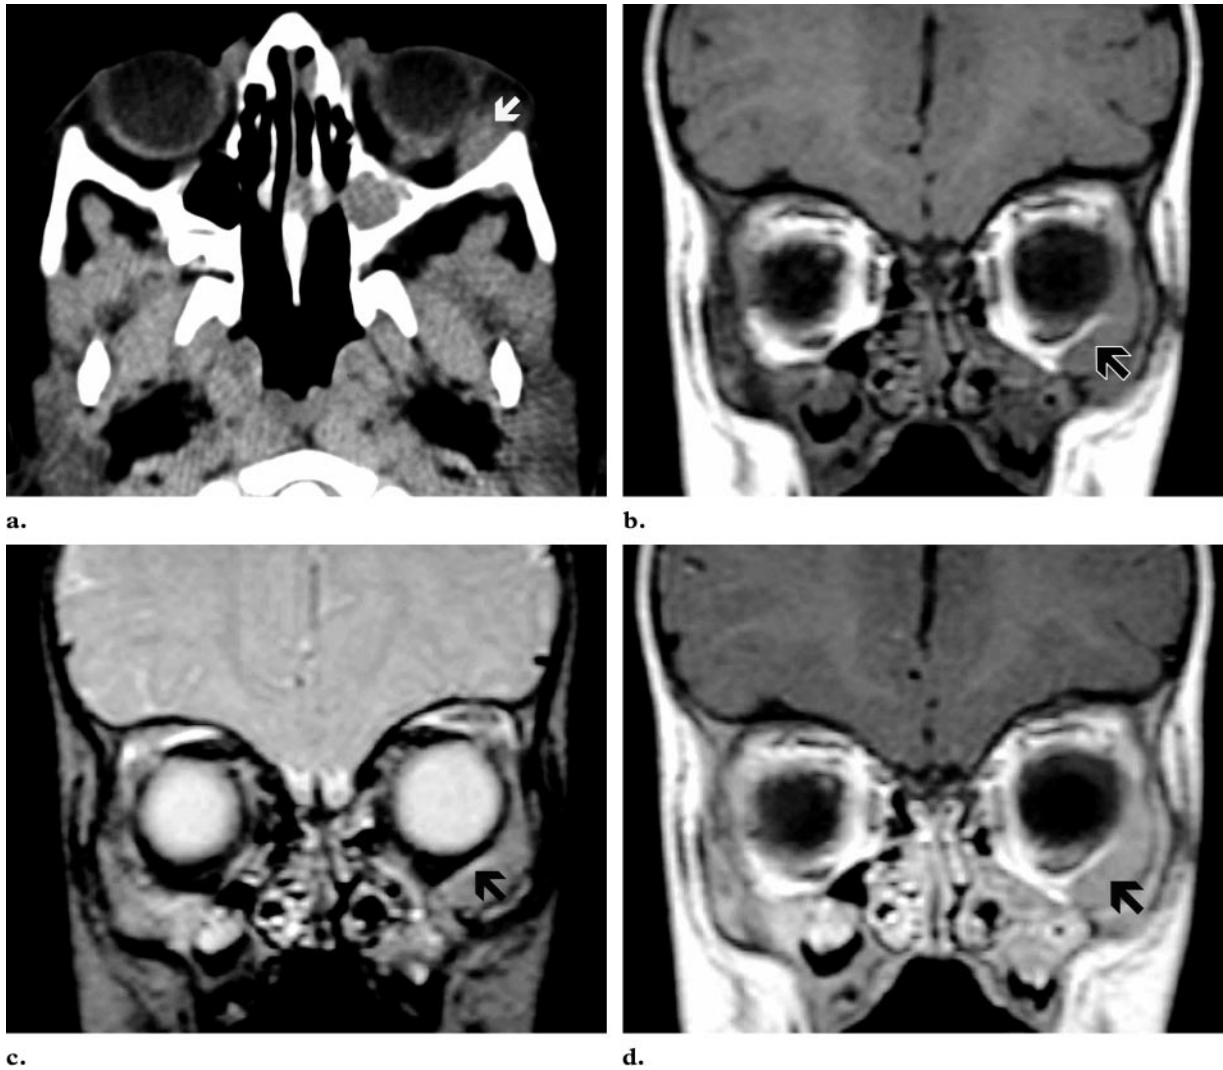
Acute myeloblastic leukemia with an orbital granulocytic sarcoma in a 1-year-old girl with a left orbital mass. Axial CT scan (a) and coronal T1-weighted (b), T2-weighted (c), and gadolinium-enhanced T1-weighted (d) MR images show a mass in the left inferior preseptal region (arrow). The mass is isoattenuating relative to muscle on the CT scan (a) with no bone involvement. It is slightly hypointense on the T2-weighted image (c) and has homogeneous enhancement on the gadolinium-enhanced image (d). Surgical biopsy demonstrated a granulocytic sarcoma.
